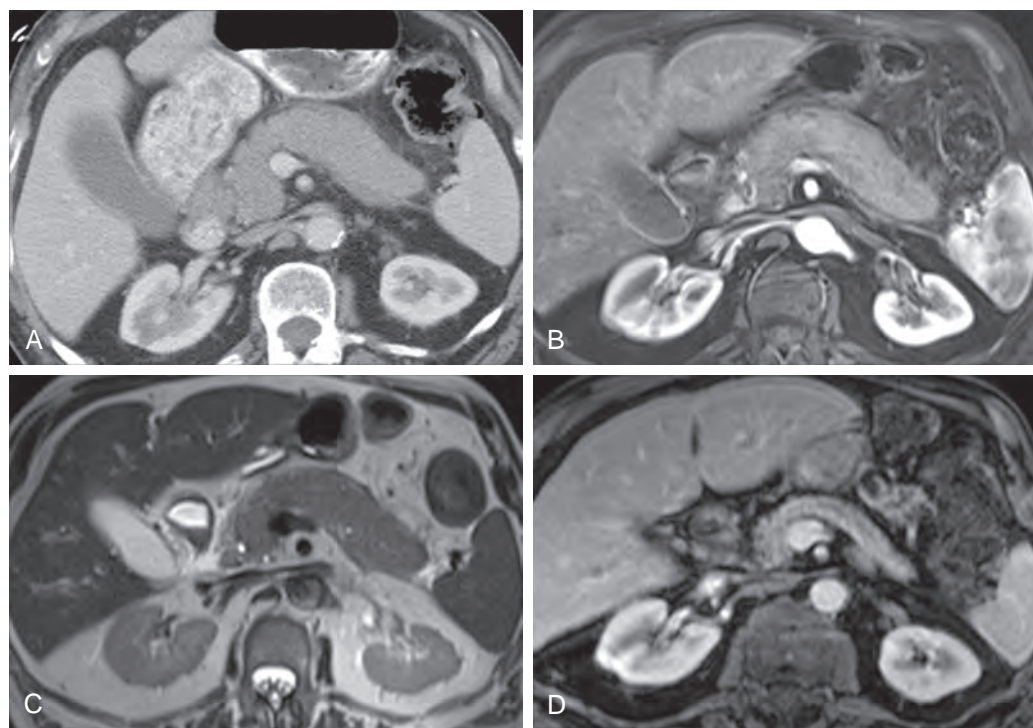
Autoimmune pancreatitis. A. Axial contrast-enhanced MDCT shows uniformly enlarged pancreas. Note peripancreatic hypodense rim suggestive but not diagnostic of autoimmune pancreatitis. B. Axial T1-weighted image shows decreased enhancement of the pancreas with hypointense rim. C. T2-weighted image shows sausage-shaped appearance of pancreas. D. Axial contrast-enhanced T1-weighted image after therapy shows atrophy of the pancreas.
